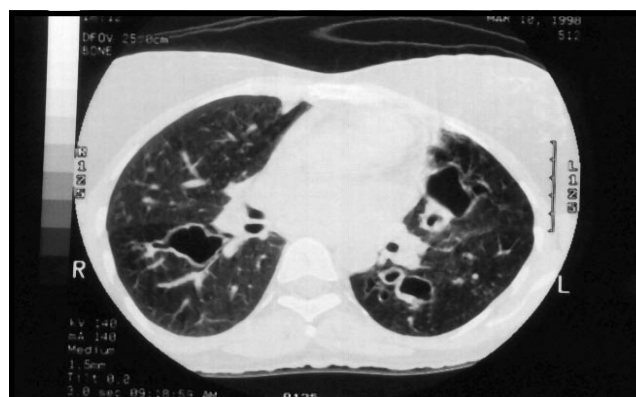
Patient 1 - High resolution computed tomography (HRCT) scan of the chest showed central bronchiectatic changes of cylindrical type affecting both lungs.
